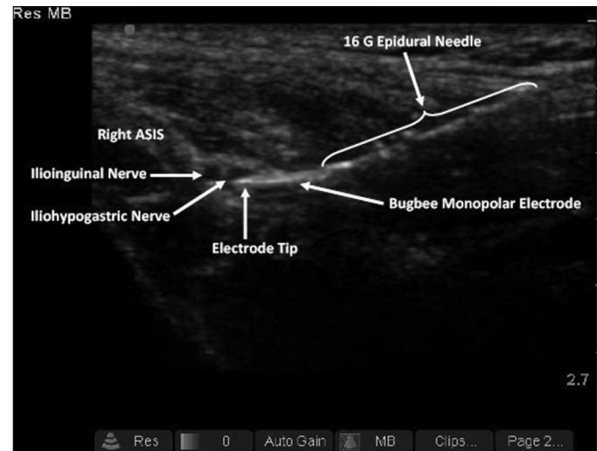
Ultrasound image showing hyperechoic electrode tip over nerve and epidural needle, placed by in-plane approach; epidural needle withdrawn away from nerve for clear vision of electrode tip
